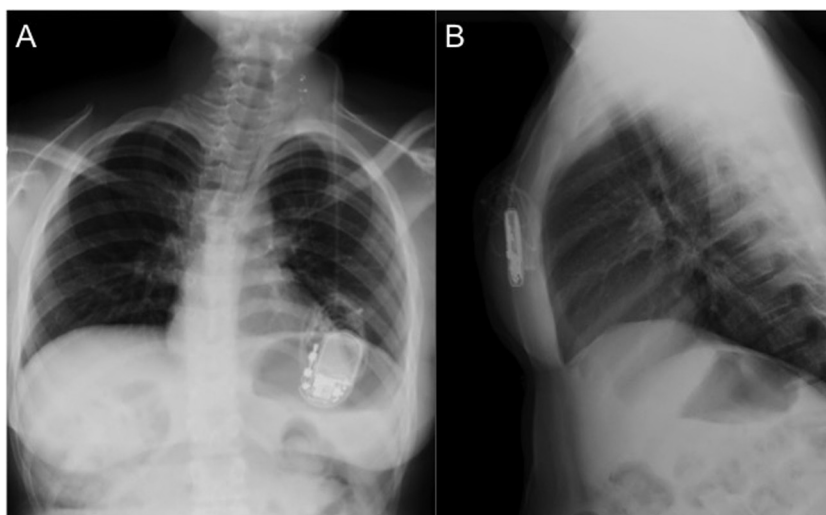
AP (A) and Lateral (B) chest x-ray performed on presentation showing migration of the VP shunt catheter into the VNS subcutaneous pocket.
